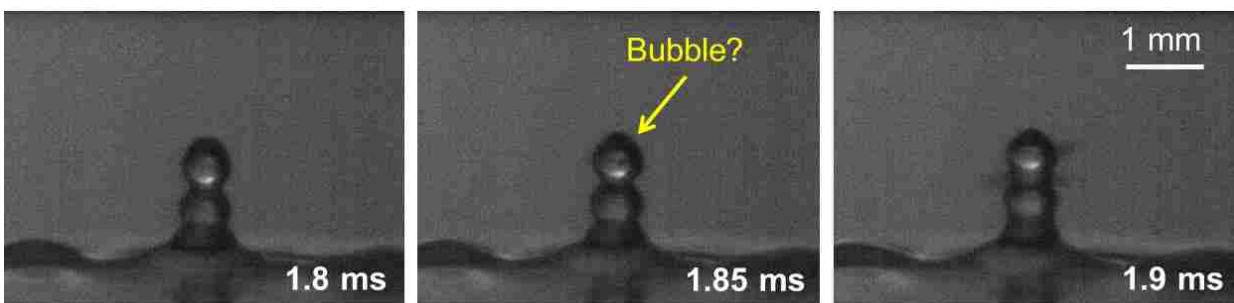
Diffusely-lighted air-water interface exposed to 2 MHz ultrasound at 180 W/cm² and filmed at 20000 fps. The first frame shows the drop chain with no jetting. The second frame shows a shadow in the top drop of the chain, which appears to be a bubble. In the third frame, which is taken only 0.1 ms after the initial frame, jets are being emitted from the drop chain at velocities up to 16 m/s. The total ultrasonic exposure was 10-ms.
